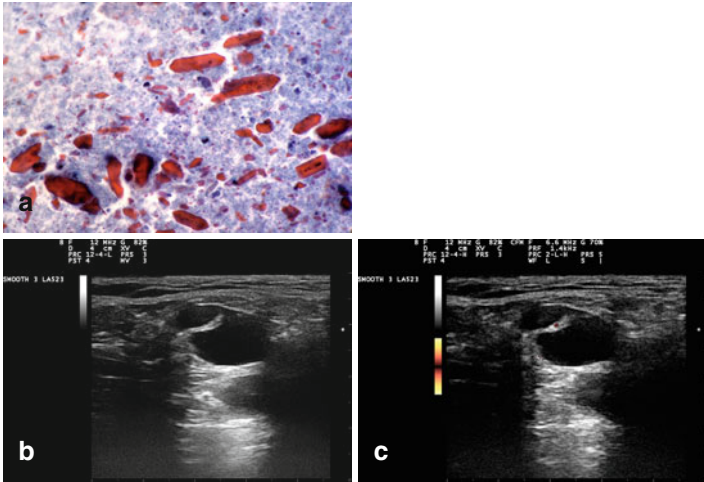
Parotid gland cyst with alpha-amylase crystals. Smear shows characteristic polyhedral and multifaceted crystals (a). US shows a septated cyst with posterior acoustic enhancement (b) and minimal vascularity in the septum by Doppler exam (c) (a SurePath preparation, high magnification)
